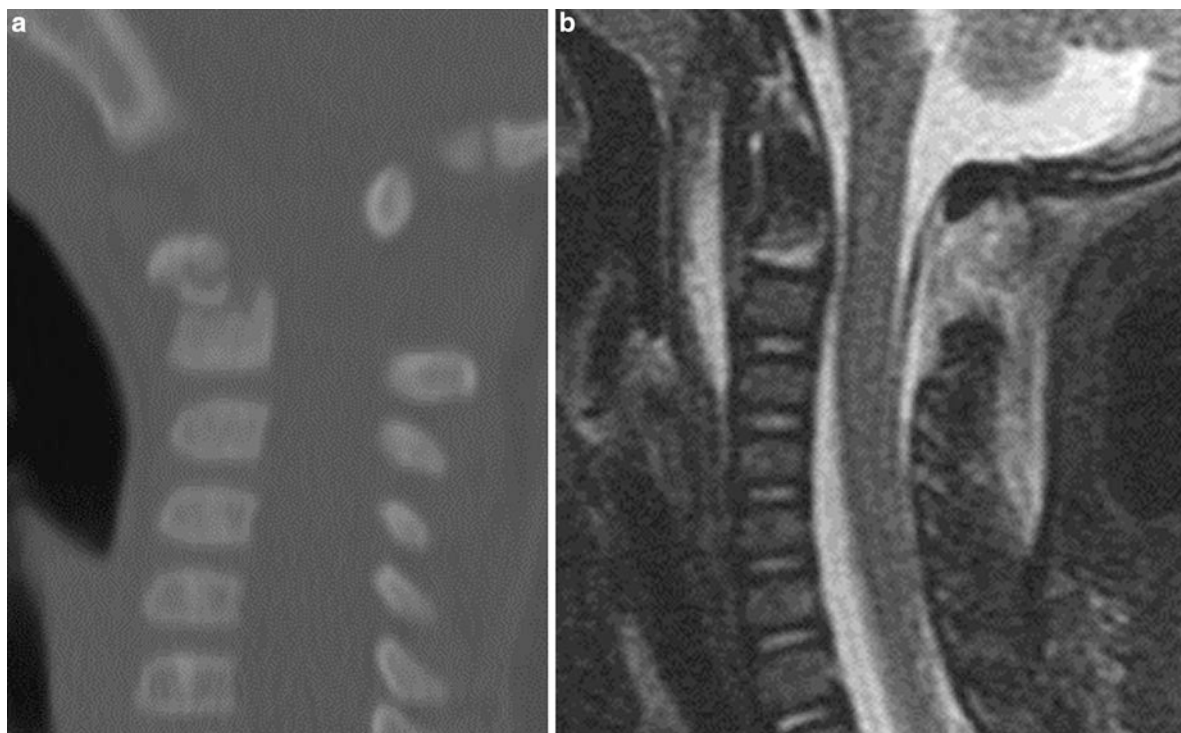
A helical (a) CT and (b) MRI scan reconstruction of C2 synchondrosis fracture in an 11-month-old
